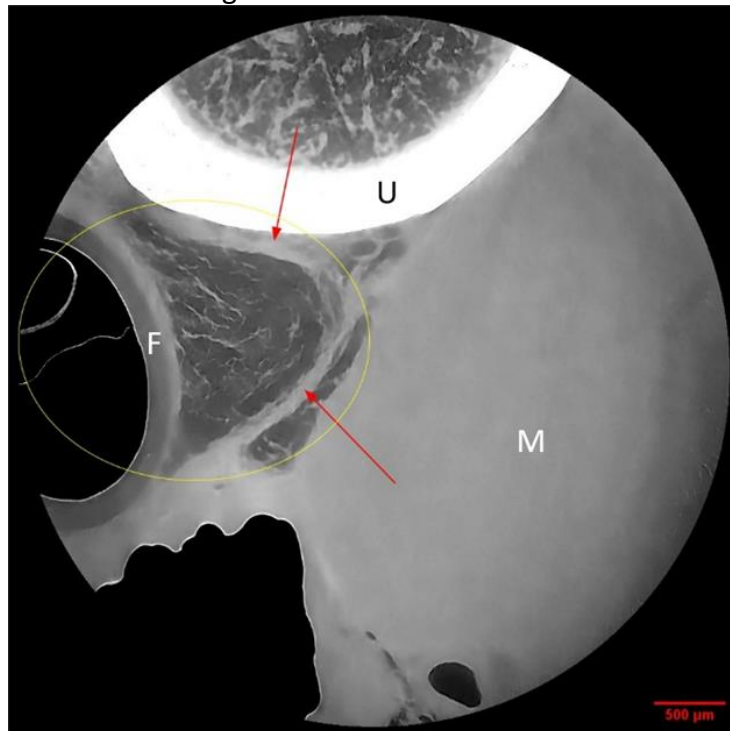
μ CT image of Wood Pigeon wing. Ulna (U), Feather (F), Musculature (M), Region of Interest (Yellow Circle/Red Arrows).
